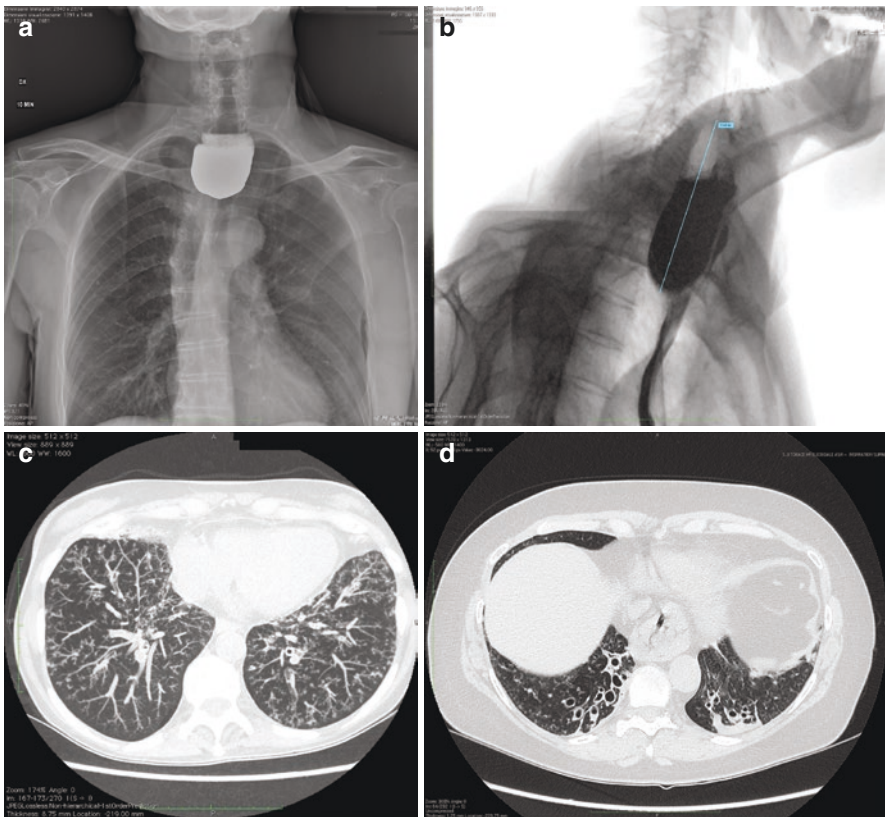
Zenker diverticulum. (a, b) VFSS examination in a 68-year-old man with dysphagia, cough, and halitosis. AP and LL views show a large Zenker diverticulum, extending inferiorly and compressing the cervical esophagus. (c, d) HRCT chest axial images show multiple bilateral centrilobular nodules and cylindrical bronchiectasis in the lower lobes. Uncoordinated swallowing, impaired relaxation, and spasm of the cricopharyngeus muscle leads to an increase in pressure within the distal pharynx, so that its wall herniates through the point of least resistance
